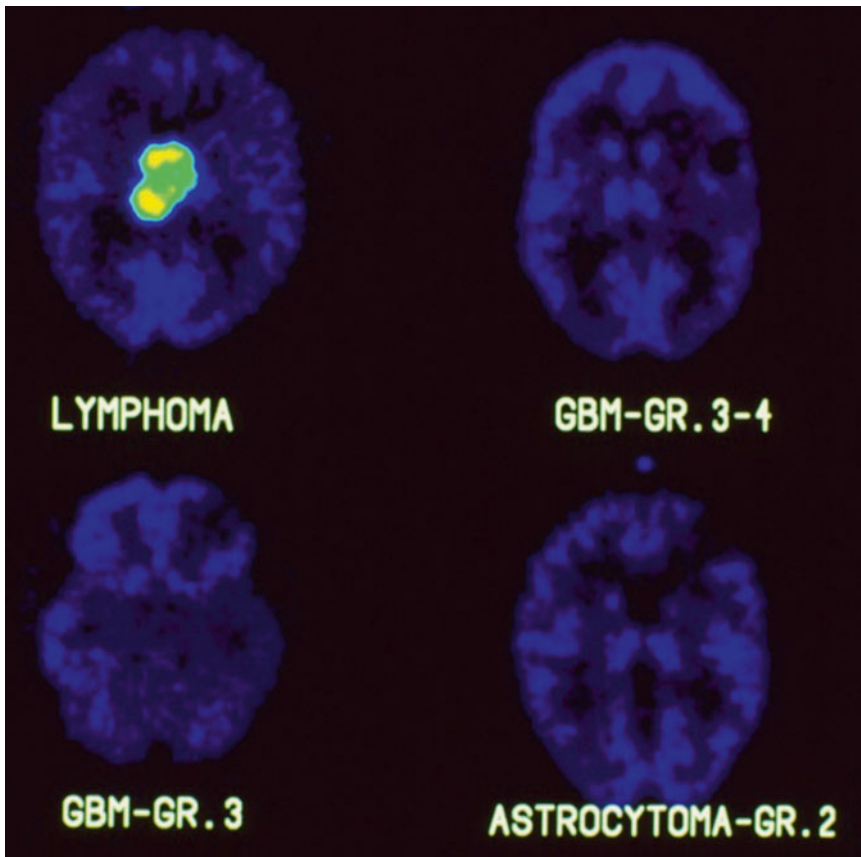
Intense metabolic activity is characteristic of CNS lymphoma as seen on 18F-FDG PET imaging
